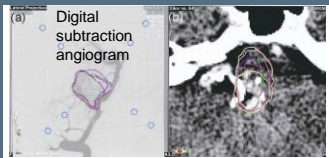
Contouring variations in a patient with a brainstem arteriovenous malformation. (a) Target volume presented as different colors. All contours were automatically projected on computed tomography images used for further analysis (b).
